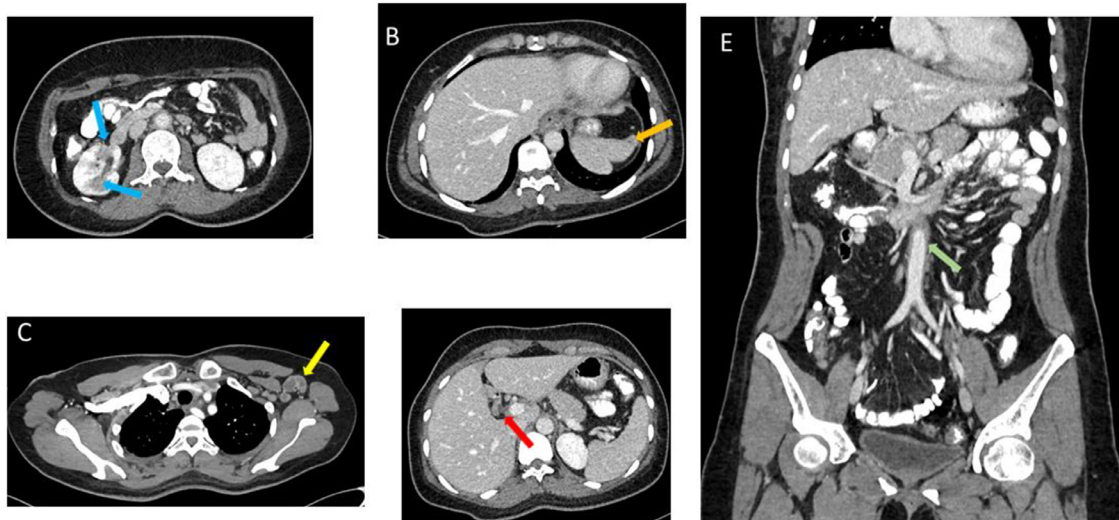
CT abdomen and pelvis with intravenous contrast (A-D) axial, and (E) coronal reformatted images showing multifocal hypo enhancing areas involving the right kidney (blue arrows), slight parenchymal heterogeneity with tiny hypodense foci in the spleen (orange arrow), mild circumferential wall thickening of the infrarenal abdominal aorta (green arrow), multiple enlarged necrotic lymph nodes in the left axilla (yellow arrow), and few prominent necrotic portal hepatis lymph nodes (red arrow).
